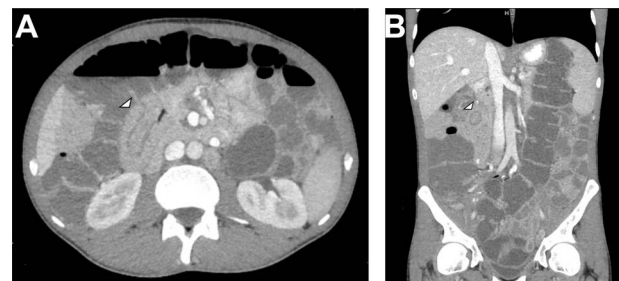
(a) Axial CT scan showing 'sausage-like' lesion; (b) coronal CT scan showing 'target' sign.
